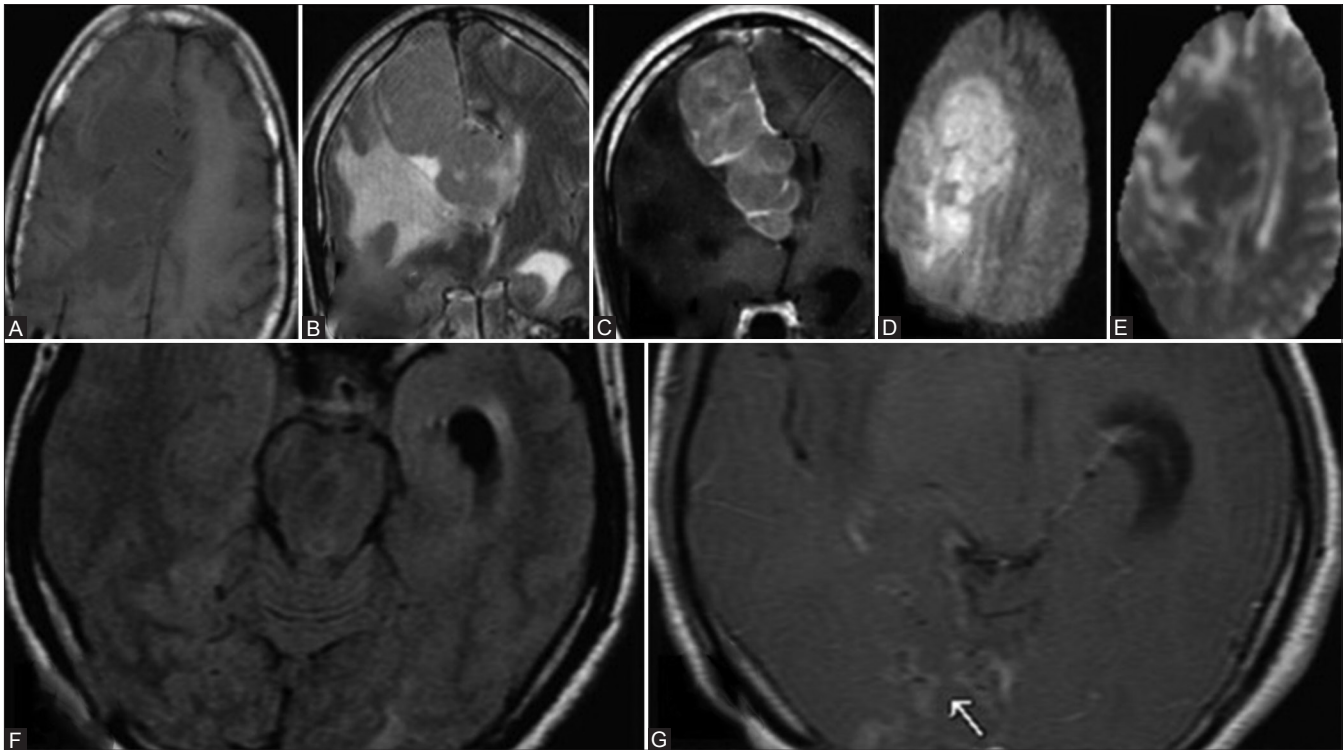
(A-G): History – A 48-year-old immunocompetent man presented with history of headache for 1 month. History of left sided limb weakness progressive in nature in the past 3 months. On MRI, there was an extra axial dural-based lesion along the right parafalcine location isointense on T1 (A), hypointense on T2 (B) that showed homogenous enhancement on post contrast study (C) and restricted diffusion on diffusion weighted and apparent diffusion coefficient images (D and E). There is resultant subfalcine herniation to the left side due to the mass effect. Subacute infarct noted in the right PCA territory seen as hyperintensity on FLAIR image (F) with gyral enhancement (arrow) on post-contrast T1 W image (G)
